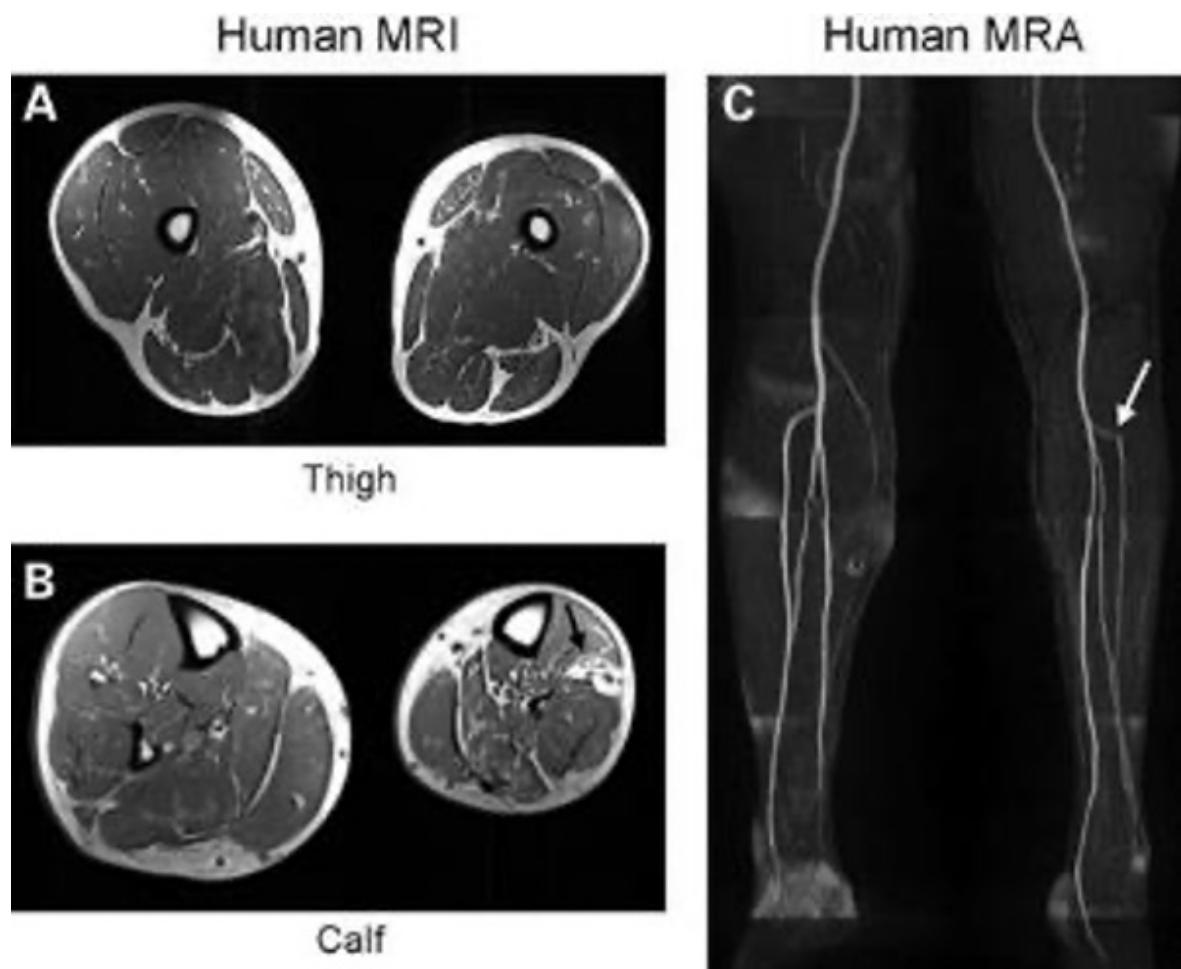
Muscle volume and vascular abnormalities in the affected clubfoot limb of an adult patient with PITX1 E130K mutation. (A) MRI shows hypoplasia of the left clubfoot limb (shown on the right) compared with the unaffected right leg on transverse sections. (B) Images obtained at calf level show more severe involvement than those taken at the thigh. Muscle hypoplasia is present throughout but is most prominent in the lateral and anterior compartments that also show a corresponding increase in fat tissue (black arrow). (C) Magnetic resonance angiograph of same patient showing reduced perfusion of the anterior tibial (white arrow) and peroneal arteries on the affected left leg compared with the right. From Alvarado et al., 2011
